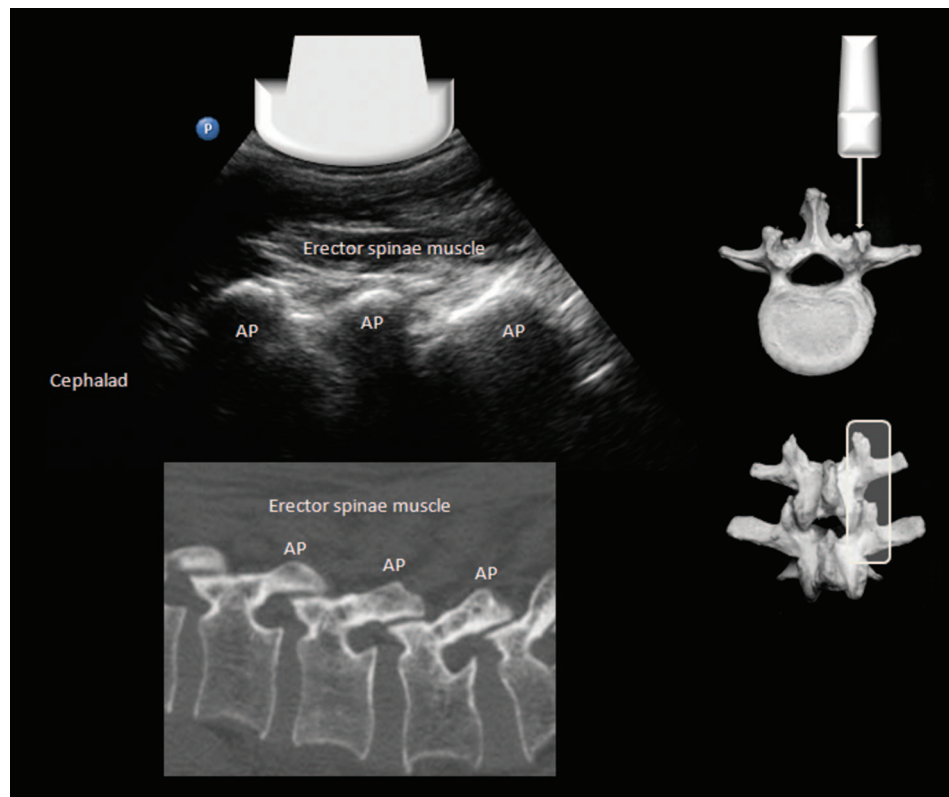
Paramedian sagittal articular process view of the lumbar spine and corresponding computed tomography image (bone window setting). The overlapping bony superior and inferior articular processes (AP) are seen as a continuous hyperechoic line of “humps” with acoustic shadowing beneath. (Image used with permission from www.usra.ca.)
